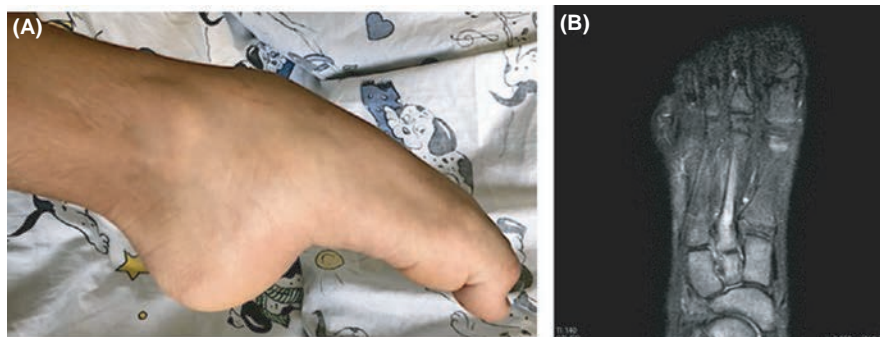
(A) Clinical aspect of right foot, which is kept in forced full plantar flexion. Ankle, midfoot, and toes are contracted, and the flexion is non-reducible for marked opposition by the child. Under general anesthesia the contracture could partially be reversed, but returned to original position upon awakening. (B) Magnetic resonance imaging of the foot showing bone marrow edema of second metatarsal bone [Colour figure can be viewed at wileyonlinelibrary.com]
